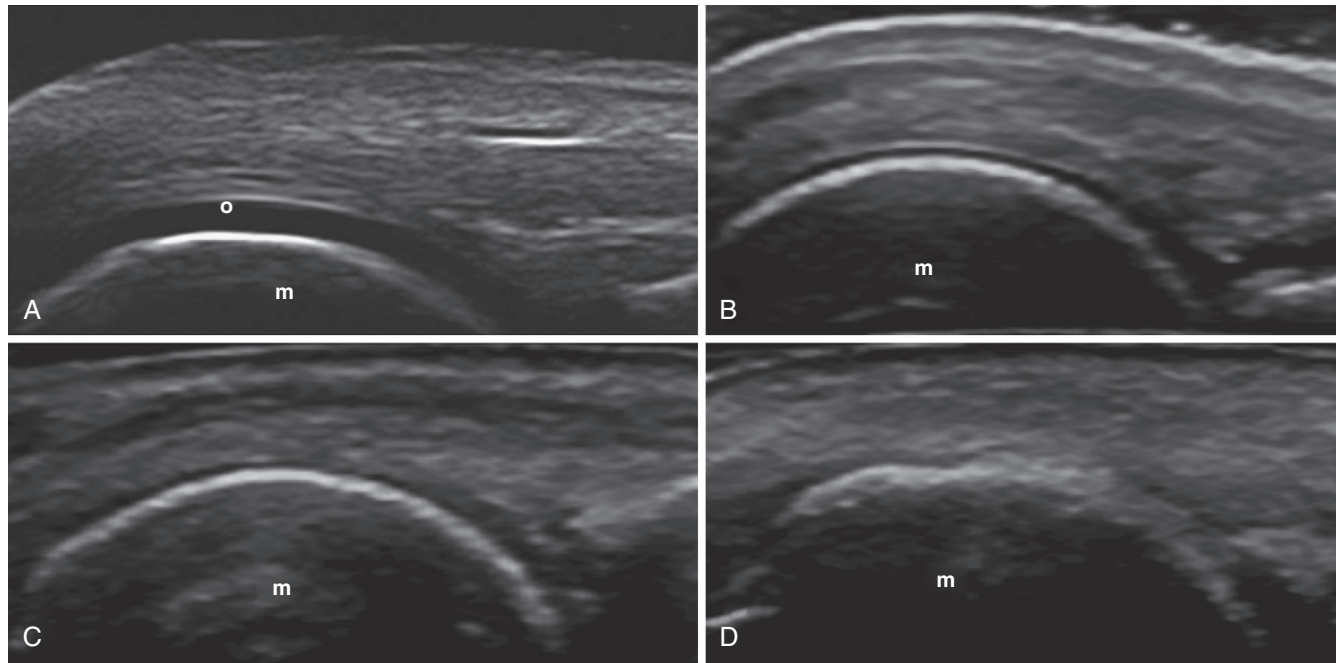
Cartilage in rheumatoid arthritis (ultrasonography). Hyaline cartilage (circle) of the metacarpal head (m) in healthy subject (A) and in patients with early (B) and advanced (C and D) rheumatoid arthritis. Loss of cartilage is homogeneous in different stages of the disease. Early (B), late (C), very late (D).
